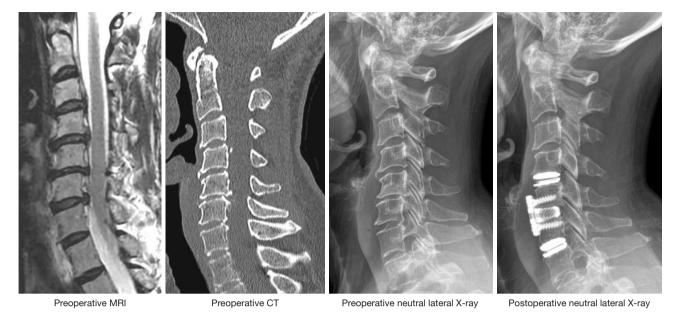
Case example demonstrating 3-level degenerative changes and kyphosis treated with ACH (arthroplasty/fusion/arthroplasty). MRI, magnetic resonance imaging; CT, computed tomography; ACH, anterior cervical hybrid.
